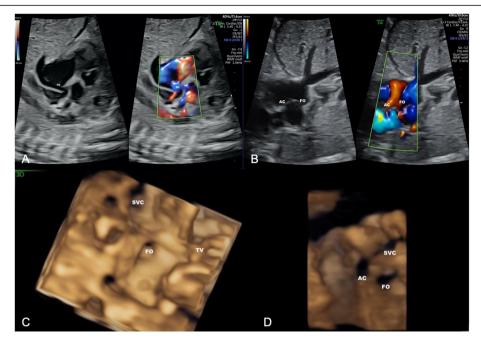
Echocardiography of the fetal heart in TGA IVS and RAS before and after fetal balloon atrial septostomy (BAS). Panel A and C represents limited blood flow across the small FO prior to BAS. Panel B and D represents blood flow across the restrictive FO and additional superior atrial communication (AC) after BAS. Panel A and B were acquired using 2-D echocardiography and Panel C and D were acquired using 3-D echocardiography. TGA, transposition of the great arteries; IVS, intact ventricular septum; RAS, restricted atrial septum; FO, foramen ovale; SVC, superior vena cava; TV, tricuspid valve
